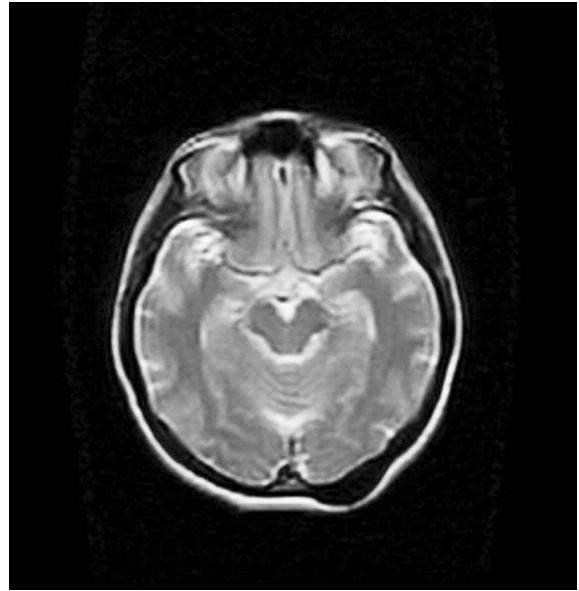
T2-weighted axial MRI revealed a hypointense lesion, on left occipital region.
